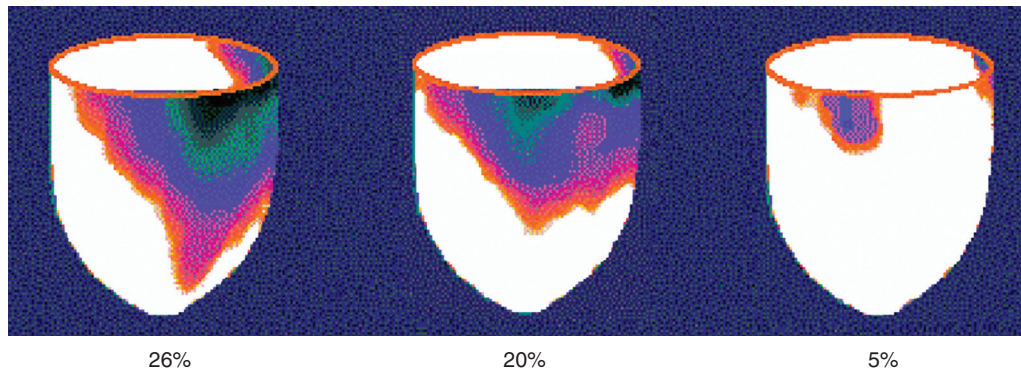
FIGURE e16-8 Improvement in perfusion after statin therapy. Three-dimensional surface-rendered models of myocardial perfusion before statin therapy (*left*) and after 6 weeks (*middle*) and 6 months (*right*) of therapy, viewed from the inferior surface of the heart. *White areas* represent normal perfusion, with *red, blue, and black* representing increasingly severe degrees of ischemia. Labels below each image show the extent of ischemia, expressed as a percentage of total myocardium. Substantial reduction in the degree of inferior wall ischemia occurs over the course of statin therapy. (Modified from Schwartz RG, Pearson TA, Kalaria VG, et al: Prospective serial evaluation of myocardial perfusion and lipids during the first six months of pravastatin therapy: Coronary artery disease regression single photon emission computed tomography monitoring trial. *J Am Coll Cardiol* 42:600, 2003.)
